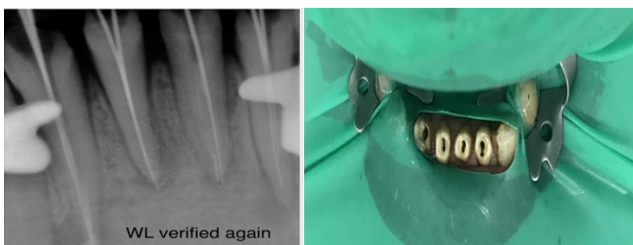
Radiograph of working length showing two different instruments in two canals of teeth (#32,31,41,42), and photograph showing two canals in each tooth
